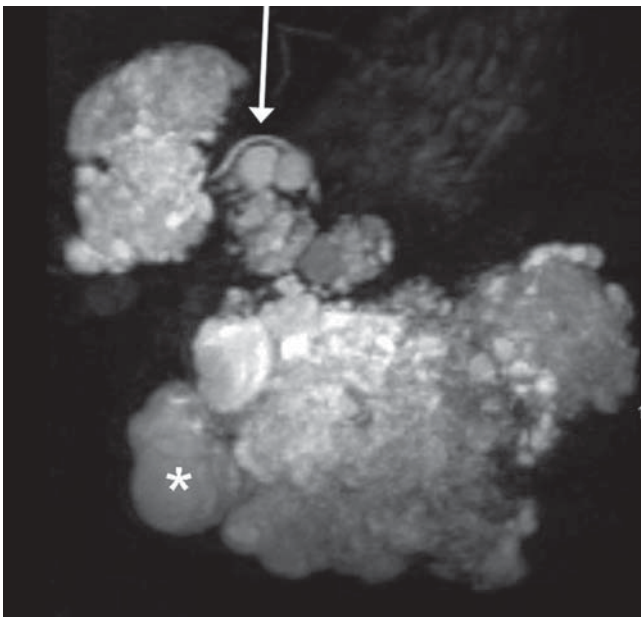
T2-weighted magnetic resonance (MR) image, showing the huge microcystic lesions surrounded by larger cysts (>2 cm; *asterisk*). The pancreatic duct does not show any signs of obstruction (*arrow*)
